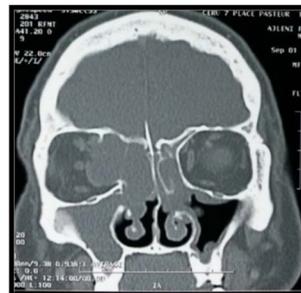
Coronal CT scan imaging showing a mass of the ethmoid with large erosion of the lamina papyracea and compressing of the orbit contents.
